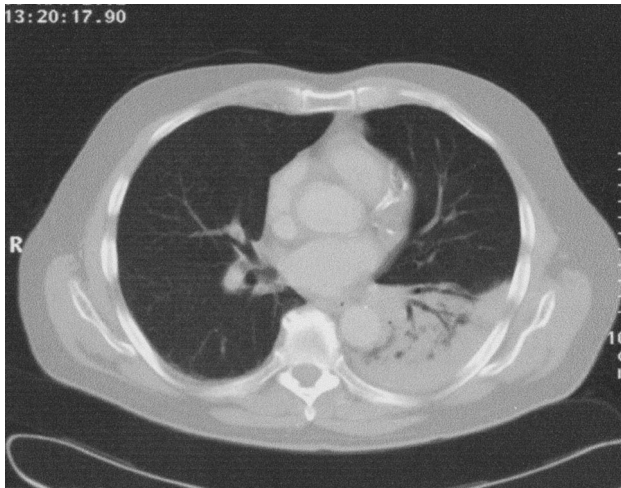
Computed tomogram showing left-lower lobe consolidation with air bronchograms.
